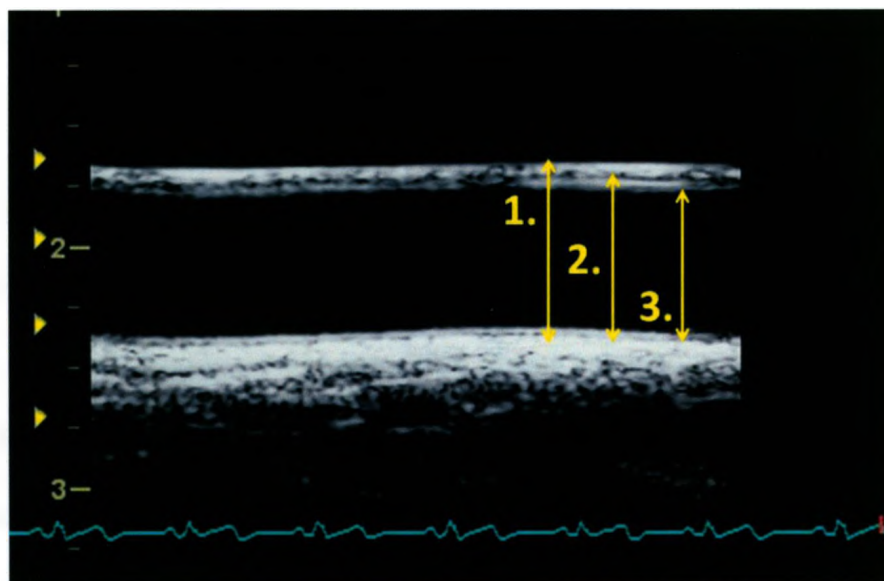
Carotid Artery Image taken in B-mode using ultrasound imaging. 1. From outer edge of anterior wall to inside the posterior wall (including the intima-media); 2. From the inner edge of the anterior wall to inside the posterior wall (including the intima-media); 3. From the outside of the intima-media of the anterior wall to inside the posterior wall (including the intima-media).
